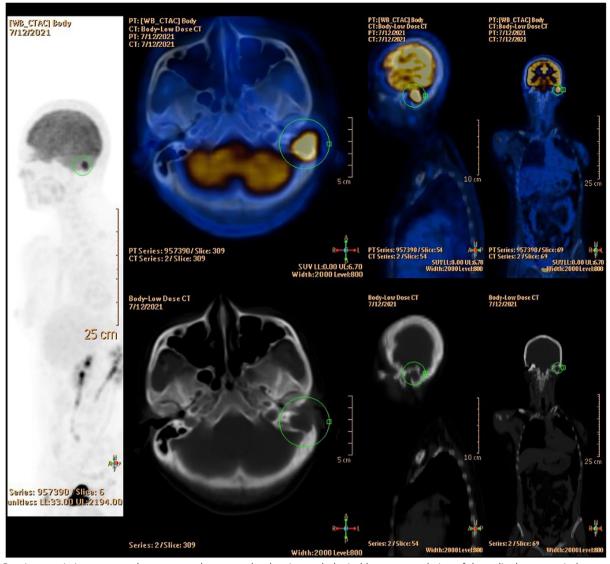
Ppositron emission tomography—computed tomography showing pathological hyperaccumulation of the radiopharmaceutical agent in the left temporal bone.
